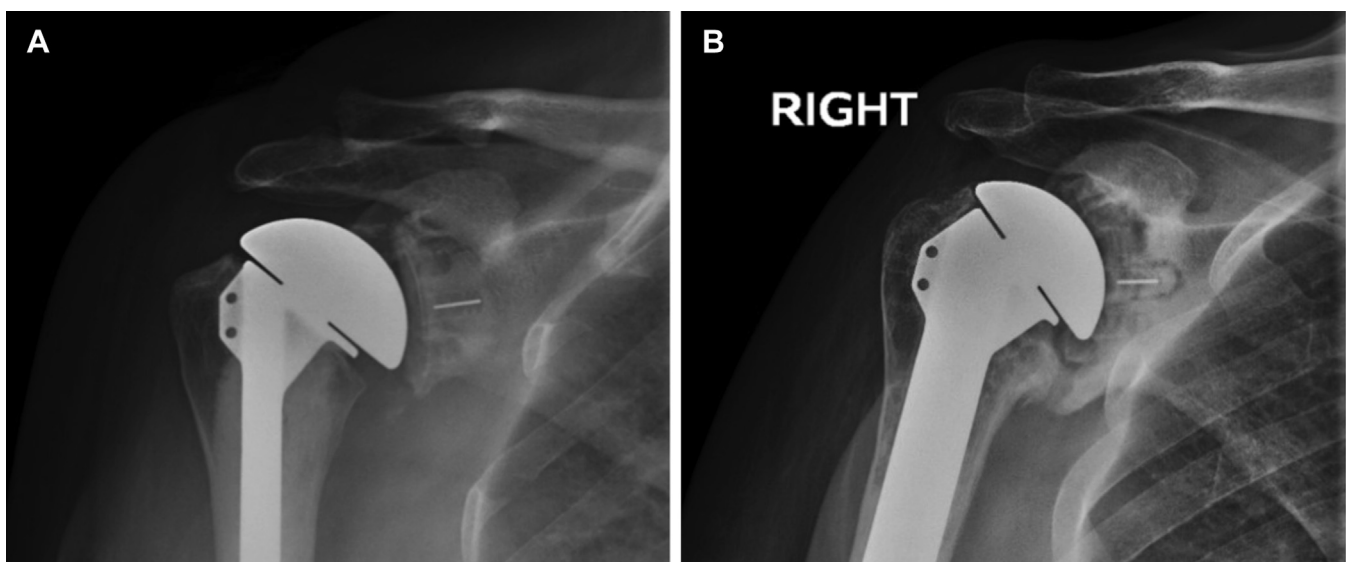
Postoperative Grashey radiographs are shown at final follow-up for 2 patients with (A) no evidence of glenoid loosening and (B) advanced glenoid loosening (grade 4).
